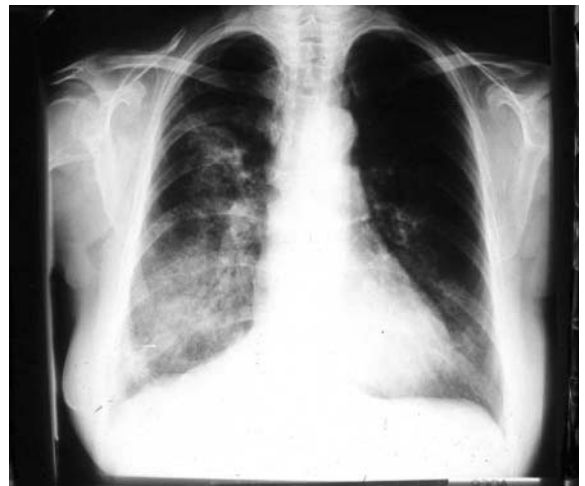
Chest radiograph in florid pneumonitis due to Wegener's granulomatosis, showing bilateral ill-defined opacities.
